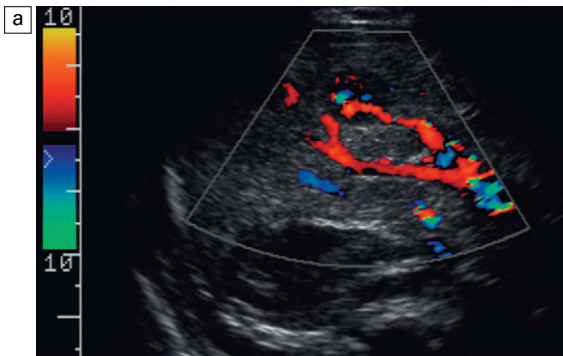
(a) Oblique colour Doppler image of the right lobe of the liver. A large feeding artery is identified with flow going into a tangled vascular malformation. (b) From this lesion flow is seen draining into a large hepatic vein. Infantile haemangioendothelioma was confirmed at autopsy.
